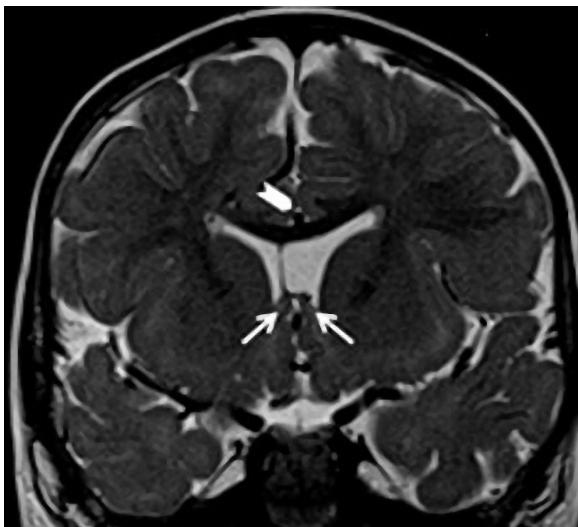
Coronal T2 weighted MRI image of our patient showing the fornices (arrows) and the close association between the right fornix and the off-midline septum; this likely represents a solitary right septal leaflet with an absent left septal leaflet. A single anterior cerebral artery (arrowhead) is seen, a common feature in disorders involving midline fusion such as SOD and HPE. arrows: fornices, arrowhead: azygous ACA.
